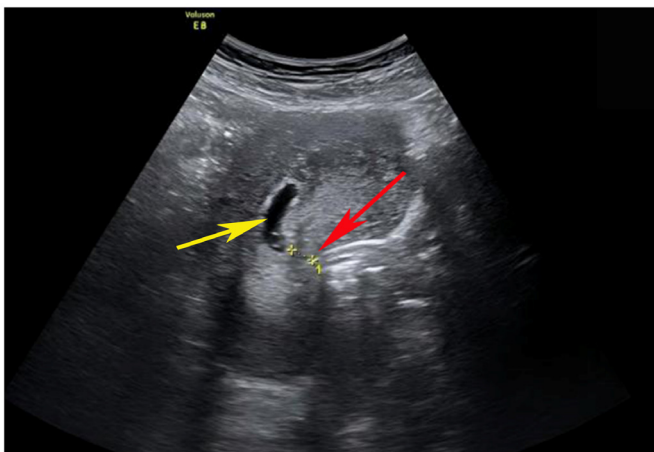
Scar incision (red arrow) in the uterine cavity and gestational sac without fetal heart (yellow arrow) are noted in the ultrasound image (case 6).
